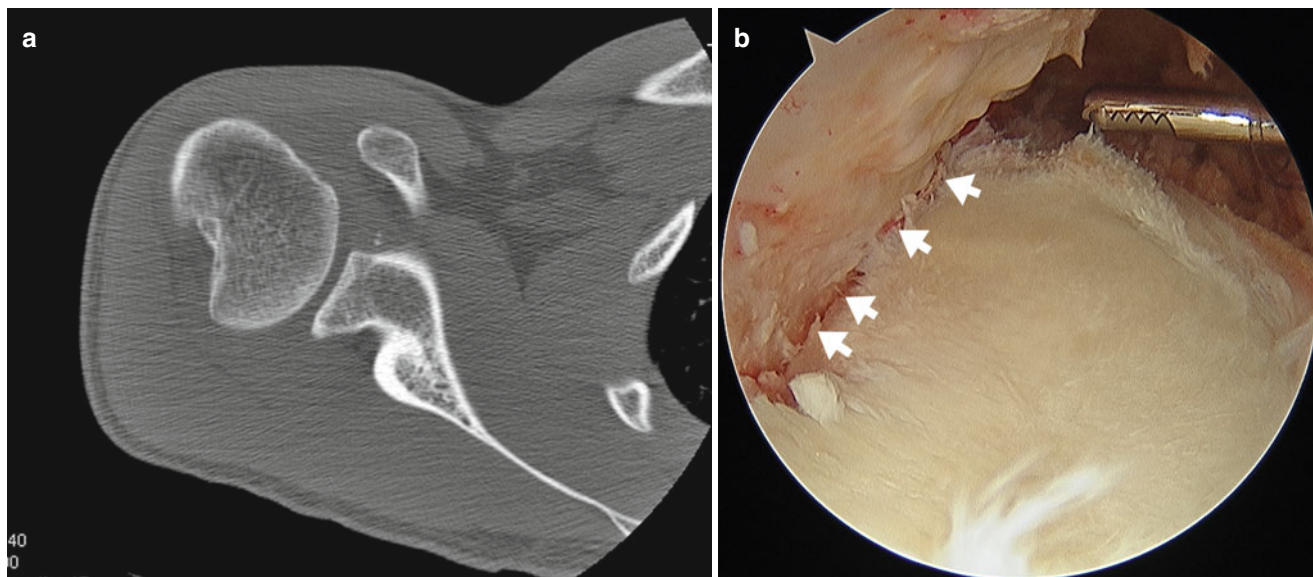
CT image of a Hill-Sachs lesion (a) and arthroscopic view of the Hill-Sachs lesion that has easy “engagement” with the glenoid (b) shown by *white arrows* marking anterior glenoid and humeral head engagement over anterior rim
